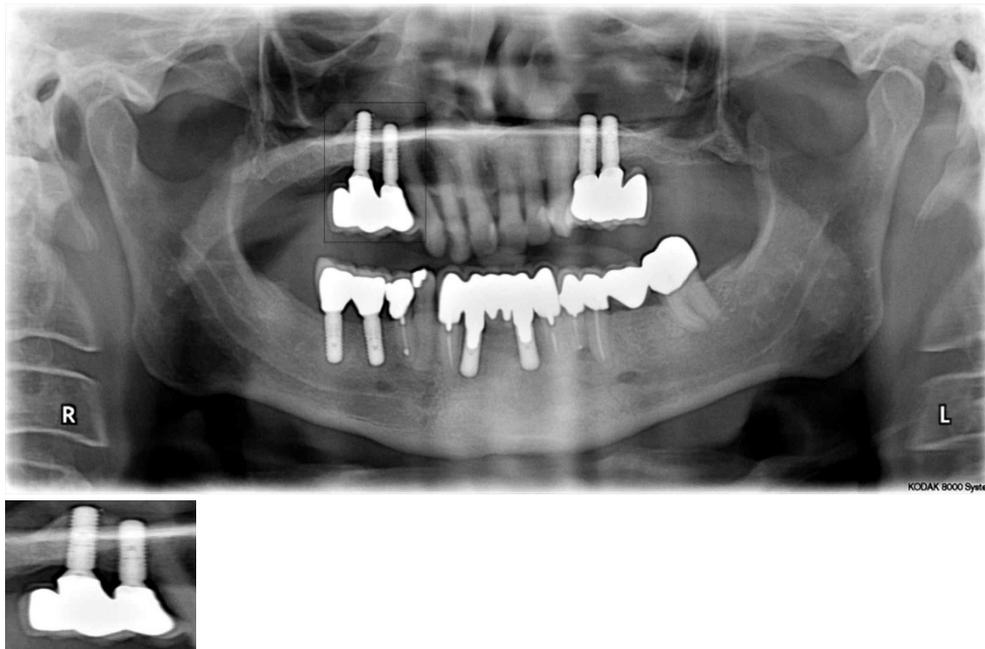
The panoramic x-ray picture one year after restoration (Bone-level implants)
